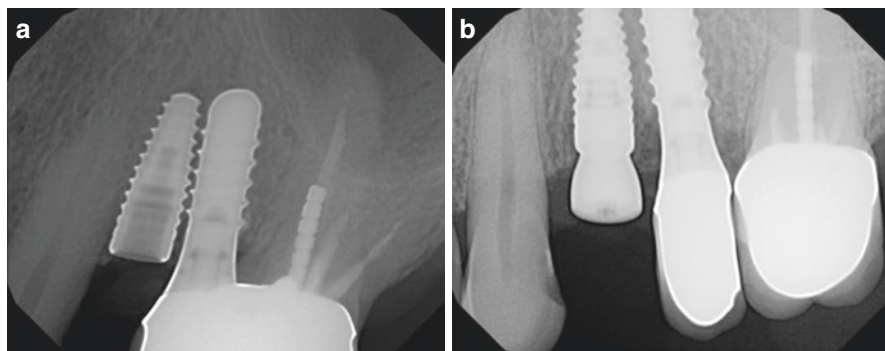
Damage to adjacent teeth. The first step is to take radiographs in different angulation. (a) A suspicious tooth damage is ruled out, (b) by taking a second X-ray in different angulation
